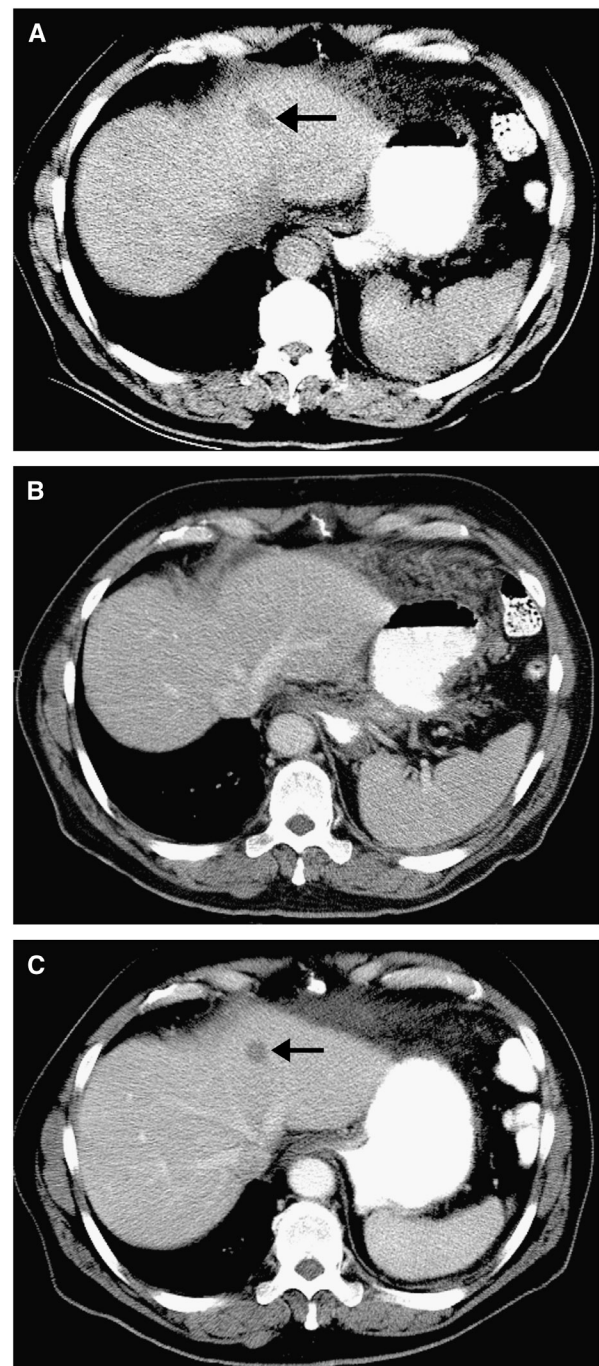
A spurious “new” lesion on follow-up CT in a 41-year-old man with primary gastrointestinal stromal tumor in the small bowel who received imatinib treatment. (A, B) On pretreatment CT, a metastatic lesion (arrow) in the liver could only be detected on an unenhanced image (A) but not on the enhanced portal-venous phase image (B), because the lesion was enhanced to the same degree as the surrounding parenchyma. (C) A portal-venous phase image of CT obtained 8 weeks after treatment showed that the lesion (arrow) became clearly visible, which should not be misinterpreted as a new lesion. Courtesy of Haesun Choi, MD, The University of Texas M. D. Anderson Cancer Center.
